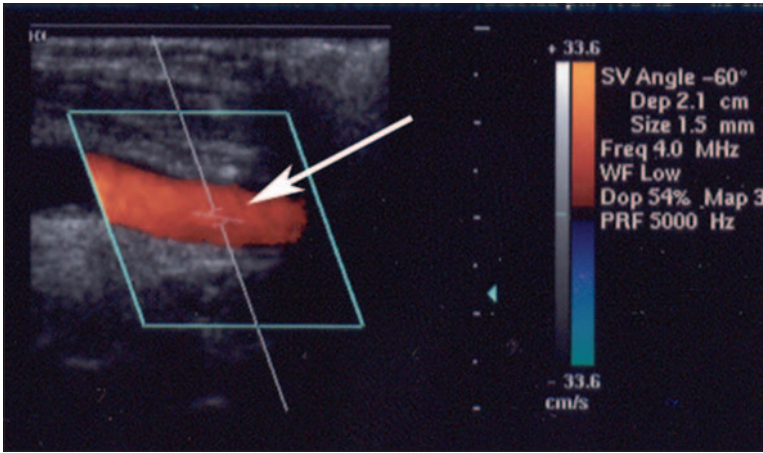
Duplex ultrasound image consisting of B mode imaging and color flow Doppler. The sample volume (arrow) can be positioned to determine the velocity at the center of the vessel lumen. Note how the angle of insonation is maintained at approximately 60 degrees.
